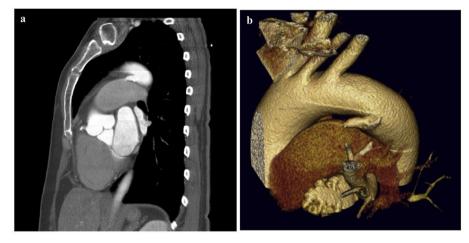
a-b. Chest CT with volume rendered images showing a large patent ductus arteriosis.
